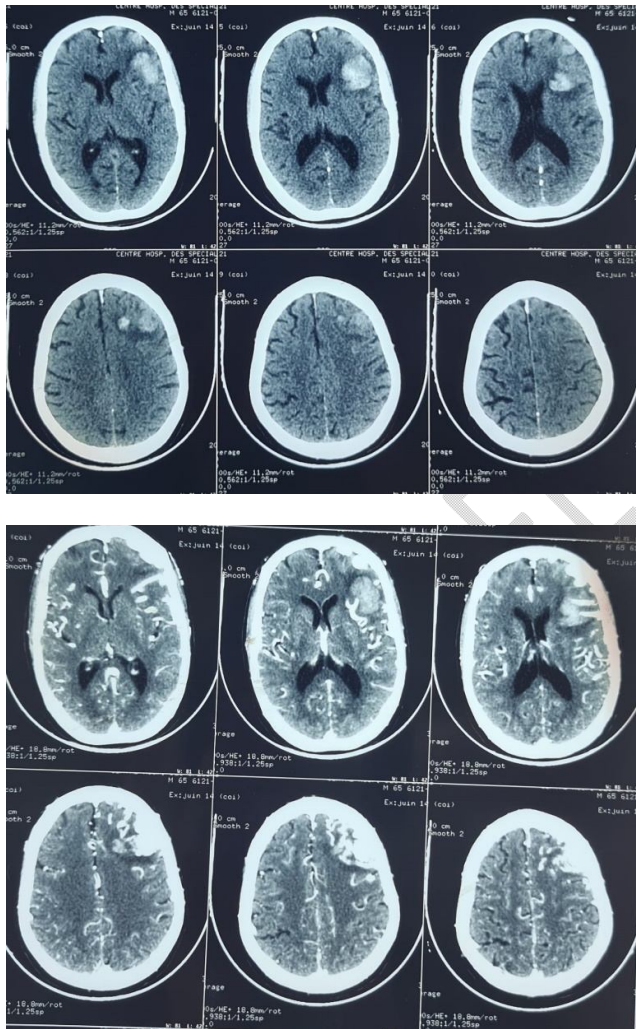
Brain CT with Agiographic sequences showing a left frontal AVM
